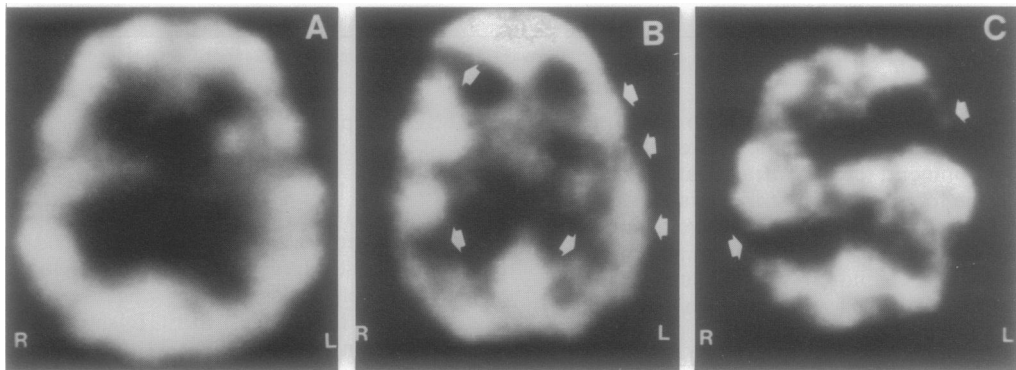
Figure Transaxial SPECT images in three children with seizure disorders. Slice level is about 4 cm above the orbitomeatal line. A=normal tomography (patient 7); B=bilateral periventricular and left cortical hypoperfusion (patient 4); C=left frontotemporal and right parieto-occipital areas of hypoperfusion (patient 14).
